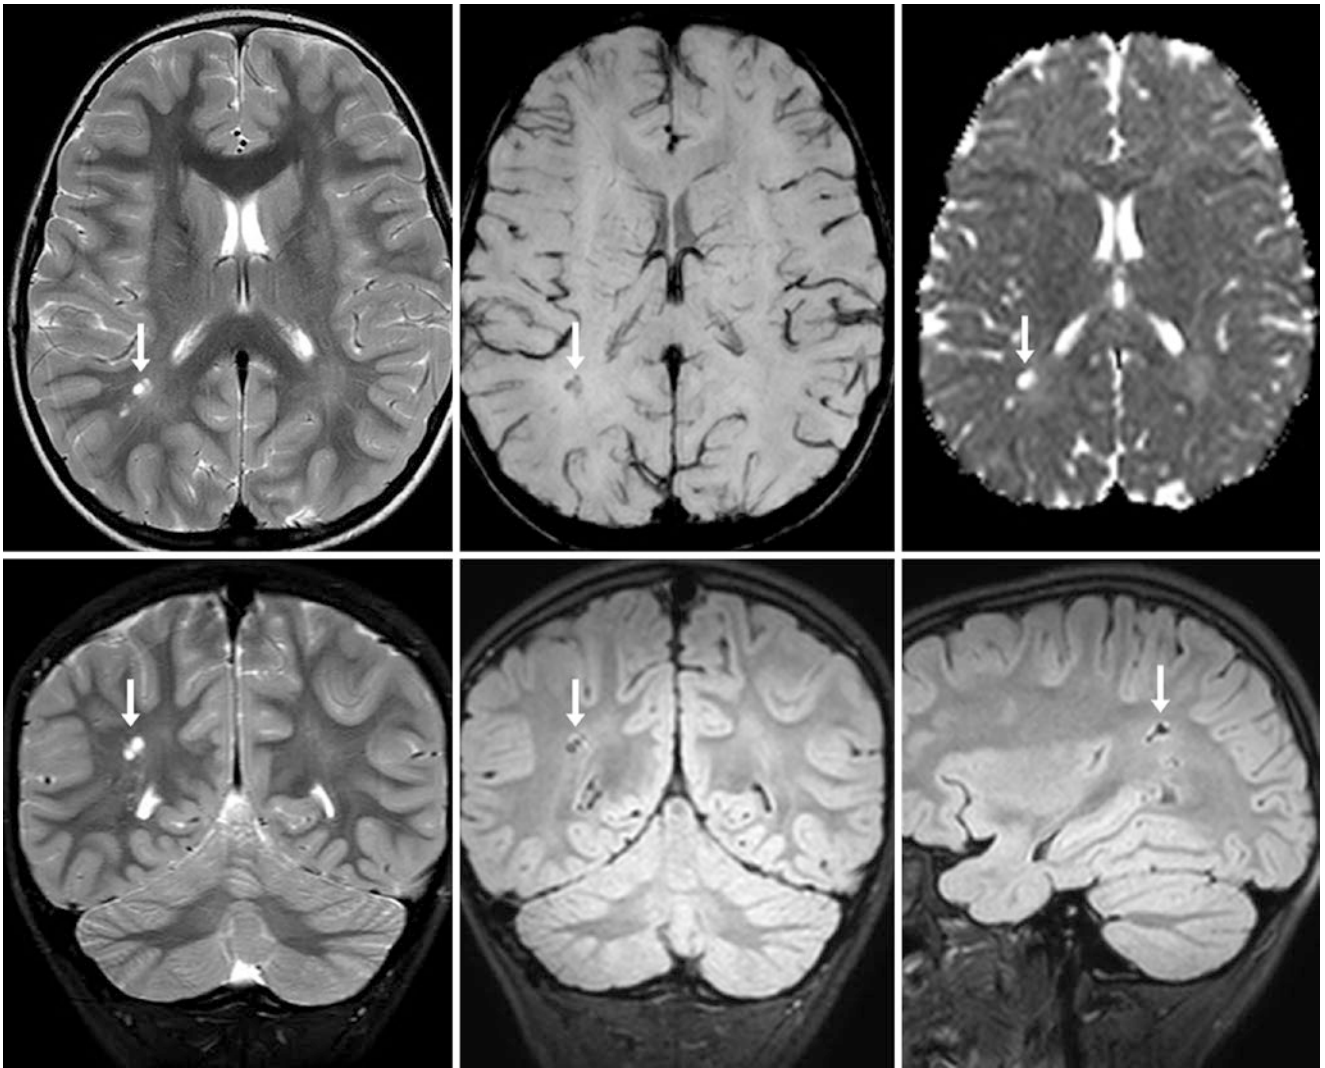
A 6 year old with nonspecific headaches had focally dilated PVSs within the right peritrial white matter (arrows) on a 3T MRI with axial T2WI (top left), SWI (top middle), an ADC map (top right), coronal T2WI (bottom left), coronal three-dimensional FLAIR (bottom
